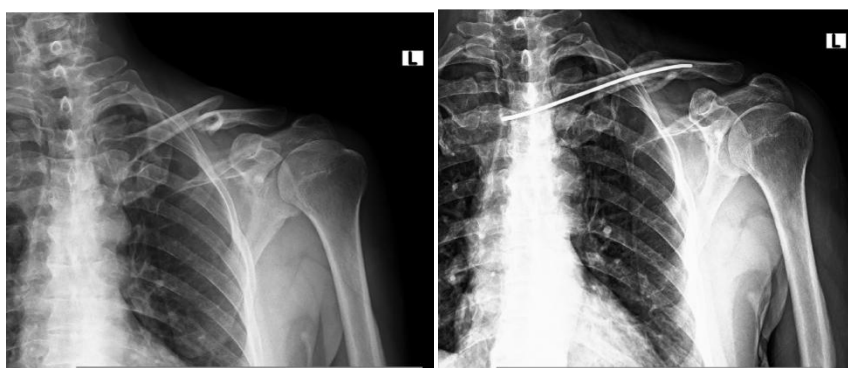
Pre-Operative & 5 month follow up X-Rays of a 30-year-old female patient with AO Type B1 Left Midshaft clavicle fracture
